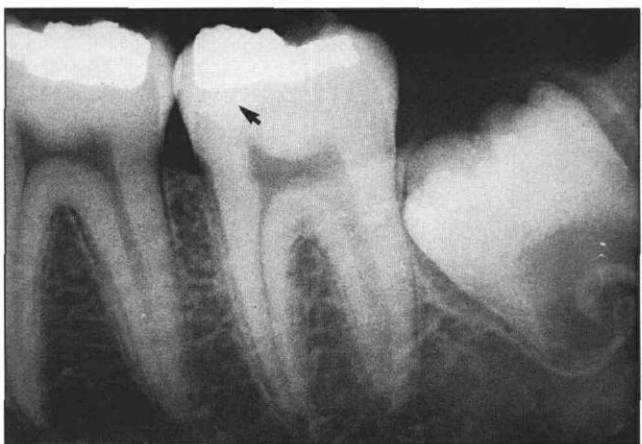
Periapical radiograph of the second mandibular permanent molar 3 years 9 months postoperative. The radiopaque area under the amalgam restoration (arrow) represents the IRM base, filling the coronal defect.
